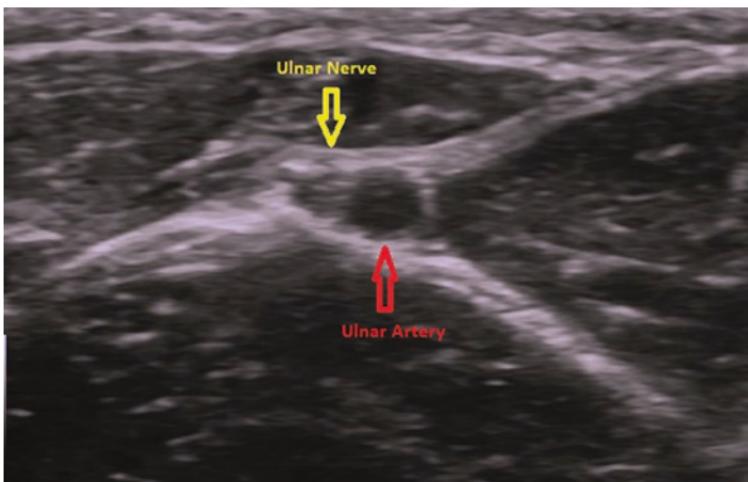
Ultrasound image of ulnar nerve at the forearm
